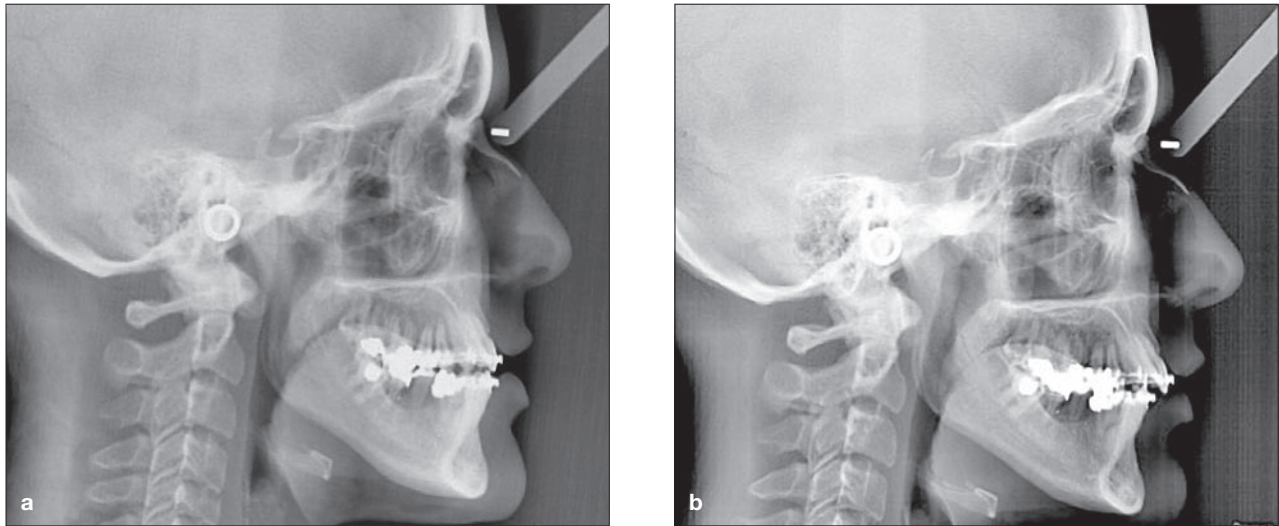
(a) Preoperative lateral cephalometric radiograph with the patient posturing the mandible forward in her habitual occlusion. (b) Lateral cephalometric radiograph with the patient in true seated condylar position.
